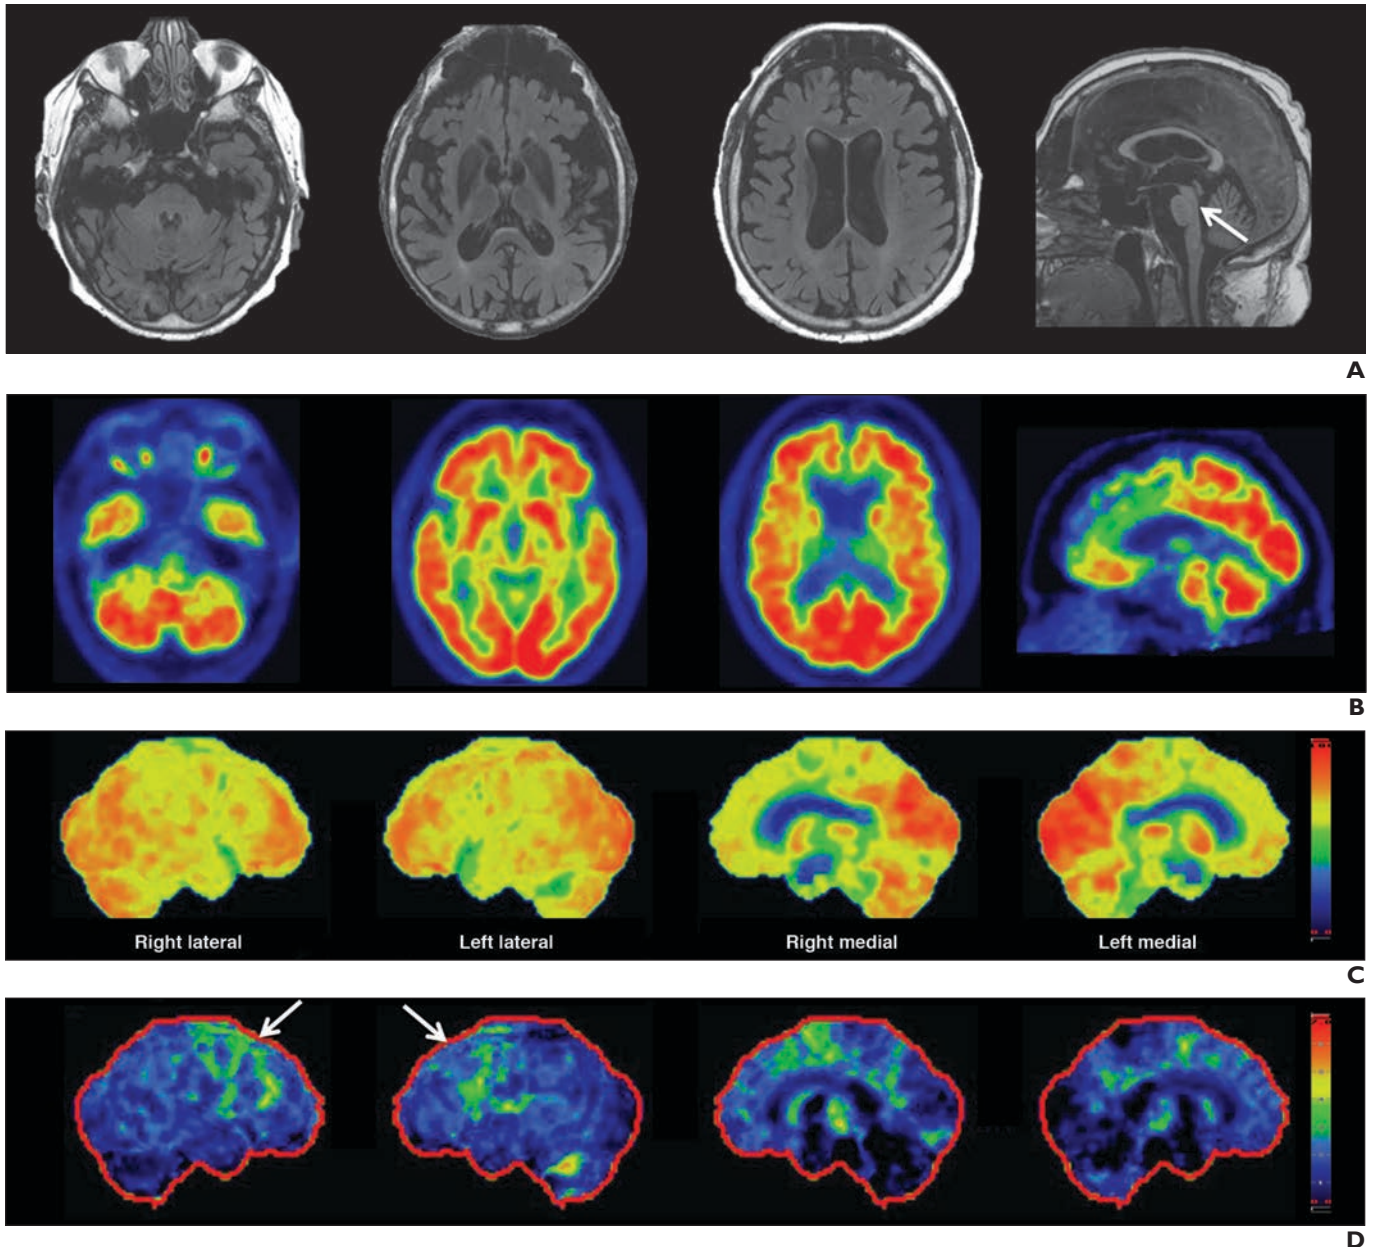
Progressive supranuclear palsy in 76-year-old woman who presented with bradykinesia, rigidity, postural instability, and pseudobulbar syndrome. A, Axial T2-weighted FLAIR images (first three images from left to right: skull base to vertex) and sagittal T1-weighted image (right image) show generalized cerebral atrophy is more prominent in frontotemporal lobes including hippocampi and perisylvian regions. Selective atrophy of midbrain tegmentum with relative preservation of pons (arrow), which is termed “hummingbird” sign, is seen on sagittal image. B and C, Axial FDG PET images (first three images from left to right, B), sagittal FDG PET image (right image, B), and sagittal 3D stereotactic surface projection maps (C) show subtle posterior frontal cortex hypometabolism. D, Posterior frontal cortex hypometabolism (arrows) is better delineated on sagittal Z-score maps.
